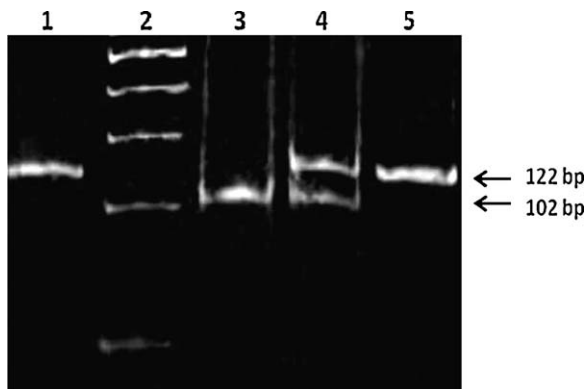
Representative gel picture for GABRG2 588C > T (rs211037) genotyping. Lane 1, undigested; lane 2, DNA ladder; lane 3, homozygous CC genotype; lane 4, heterozygous CT genotype; lane 5, homozygous TT genotype.
